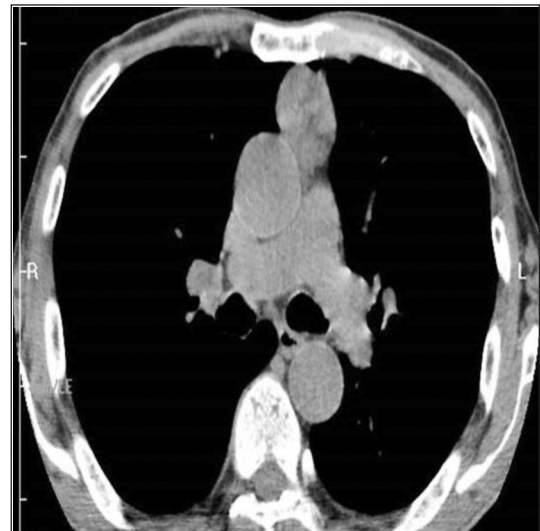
Chest CT of the patient revealed a mass located in the antero-superior mediastinum and it was compatible with thymic lesion.
